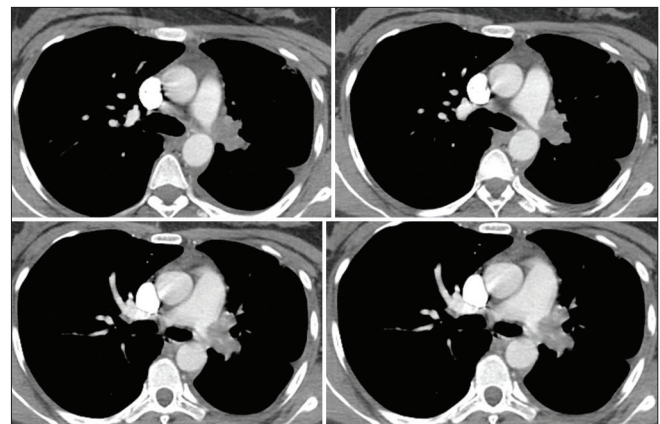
Thorax computed tomography angiography: Mass lesion (3 cm of its widest area) that almost totally obstructs the lumen of the left pulmonary artery and follows its branches
